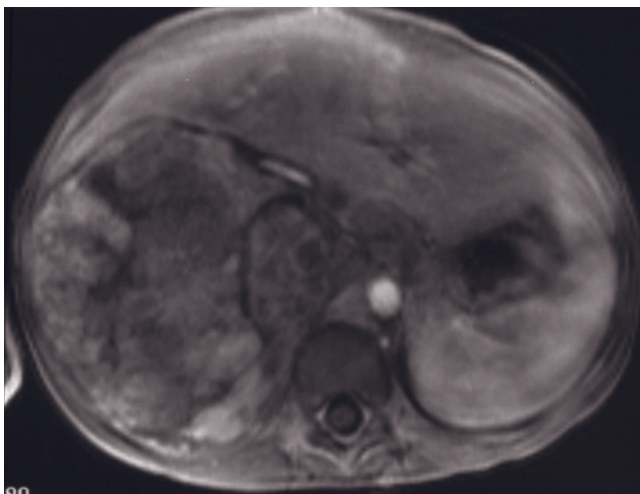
Hepatic metastases from neuroblastoma. T1-weighted fat-suppressed spin-echo (a) and T2-weighted fat-suppressed echo-train spin-echo (b) images. The liver is massively enlarged, compressing the pancreas (arrows, a). Multiple liver metastases are present, which appear minimally hypointense on T1 and markedly hyperintense on T2. The primary tumor in the right adrenal (large arrow, b) and contralateral involvement of the left adrenal (small arrow, b) have similar signal intensity. Neuroblastoma has a tendency to local infiltration, lymph node metastases, and hematogenous spread to liver, lungs, and bones.
